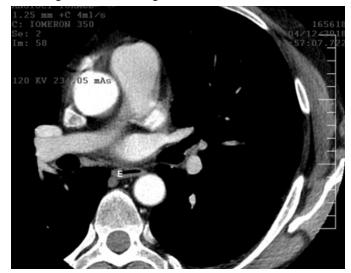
Computed tomography of the heart. The Esophagus is posterior structures, being situated between the heart and the descending aorta. In this image the esophagus is posterior o the left atrium, behind the right superior pulmonary
